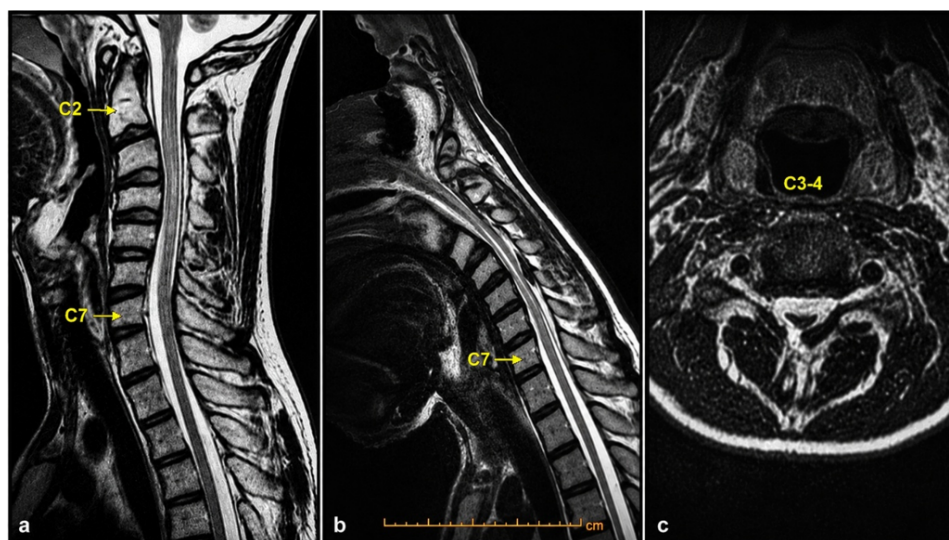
Sagittal T2 weighted MR image in neutral position shows anteriorly displaced posterior dura along with enlarged epidural space at the level of C3, C4 and C5 vertebra (a) and reversal of cervical spine lordosis (kyphosis). Flexion T2 weighted MR image demonstrates exaggeration of dural detachment with compression on cord and prominent flow voids in widened epidural sac. (b) High signal intensity can be seen in the upper cervical cord, accompanied by atrophy of cord. Asymmetric flattening of cord, more on the right side, along with dural detachment can be observed on axial T2 weighted MR images obtained at the level of C3-C4 vertebra (c).
